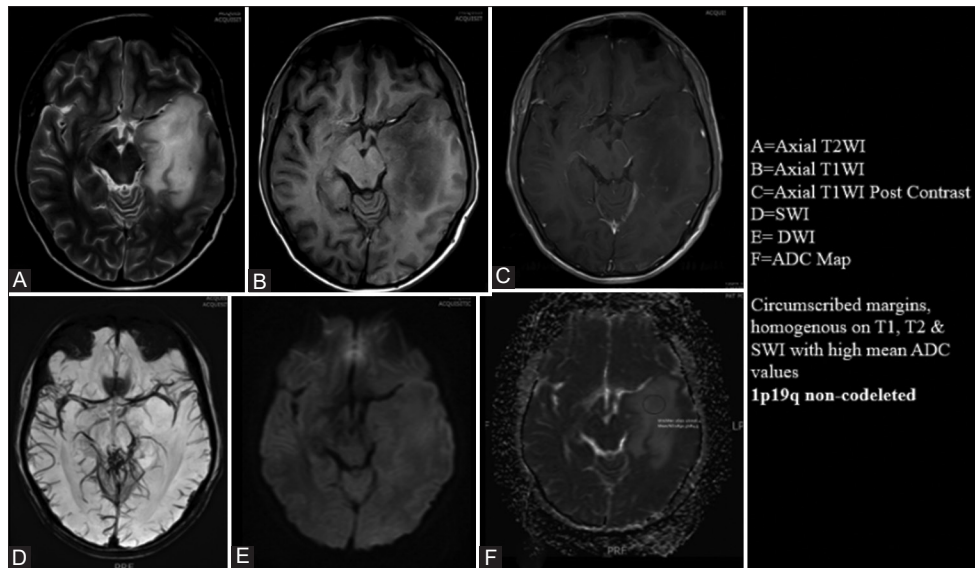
Sample of magnetic resonance imaging in a patient without 1p/19q codeletion
